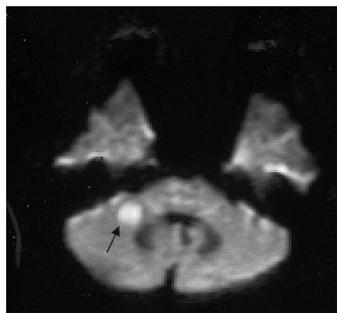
Diffusion axial MRI scan showing right middle cerebellar peduncle ischemic change.
